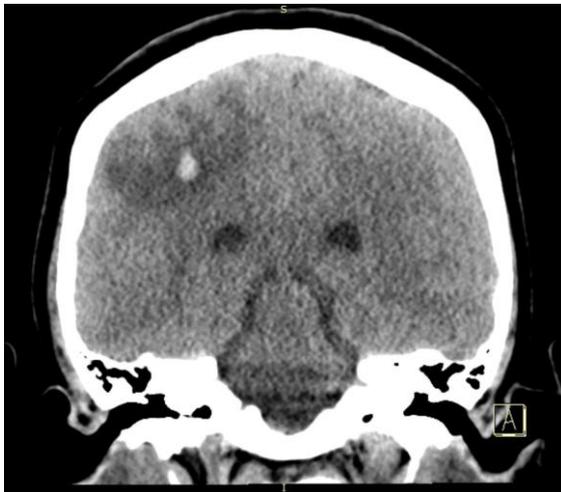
Coronal CT w/ Focal 6mm Hemorrhage with surrounding vasogenic edema and thrombosis in surrounding Cerebral Veins.
